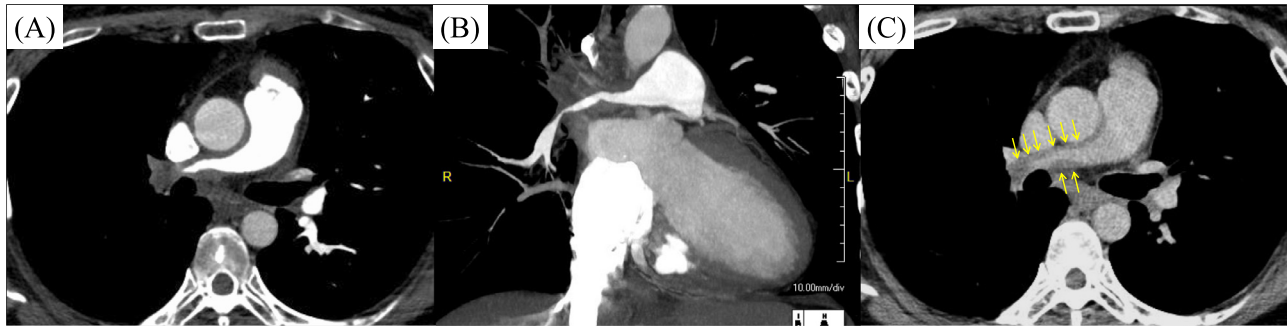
Contrast-enhanced CT images. Early phase demonstrates extensive proximal narrowing in the right main pulmonary artery (A and B). Delayed phase shows thickened walls with enhancement (C).
